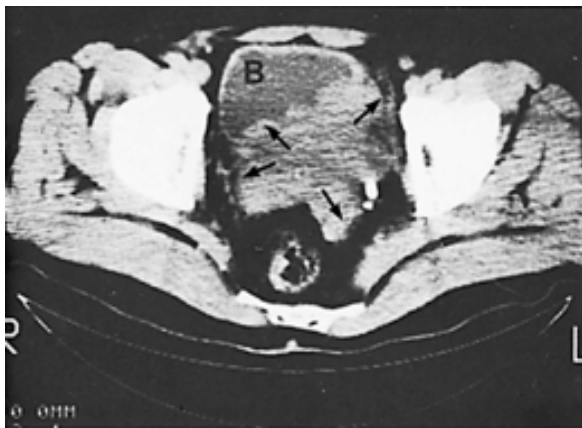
Pelvic computed tomography scan demonstrating local extension of prostate cancer with involvement of the bladder (*upper arrows*) and seminal vesicles (*lower arrows*). The left ureter (contrast enhanced) appears to be dilated as it approaches the tumor mass. (From Spirnak J, Resnick MI. Clinical staging of prostatic cancer: new modalities. *Urol Clin North Am* 1984;11:221, with permission.)
